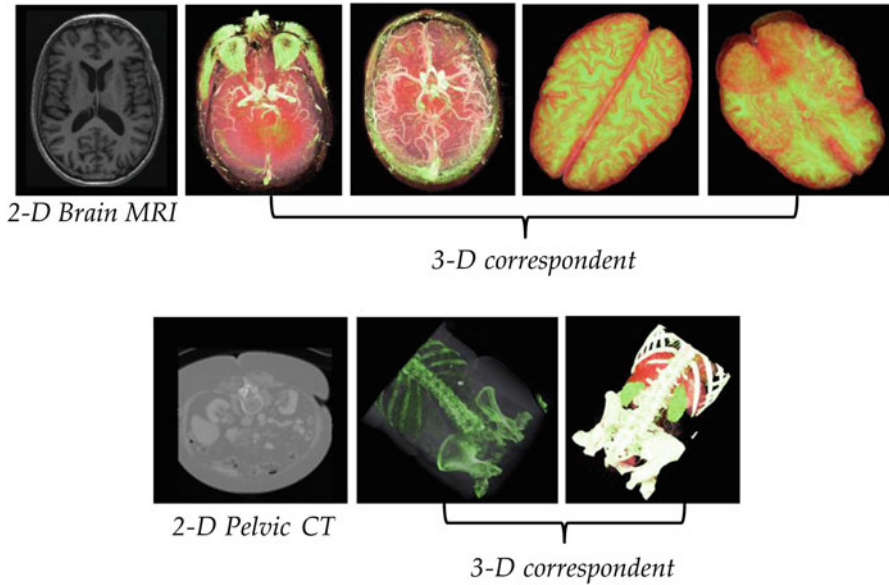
Sample 2-D slices, as being obtained from *MRI* and *CT* machines, and the correspondent 3-D reconstructions (Adeshina et al. 2012, 2013)
